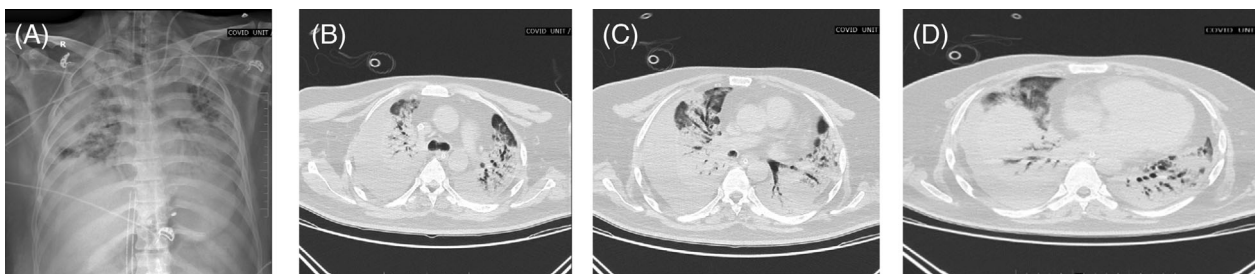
(A–D) Chest x-ray and computed tomography of the thorax after almost a month of COVID-positive report (24 October)
